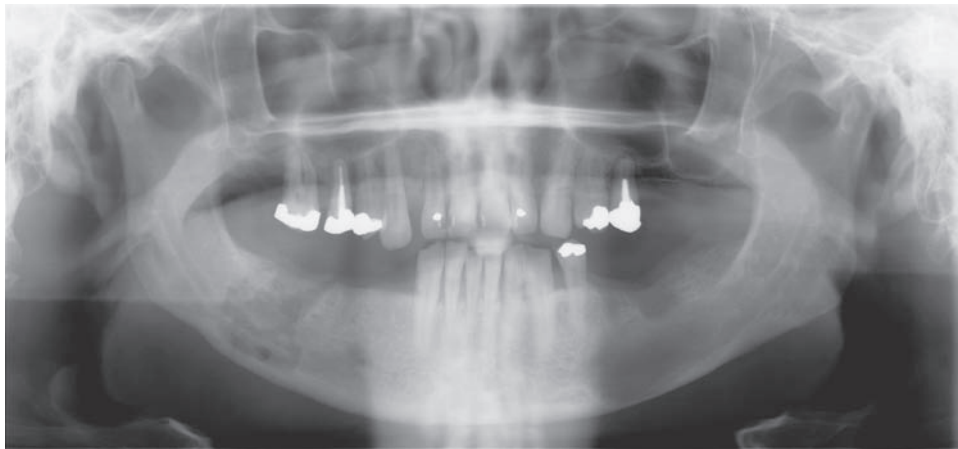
Panoramic radiograph showing osteomyelitis. (Courtesy of Dr. Michael Bornstein.)
